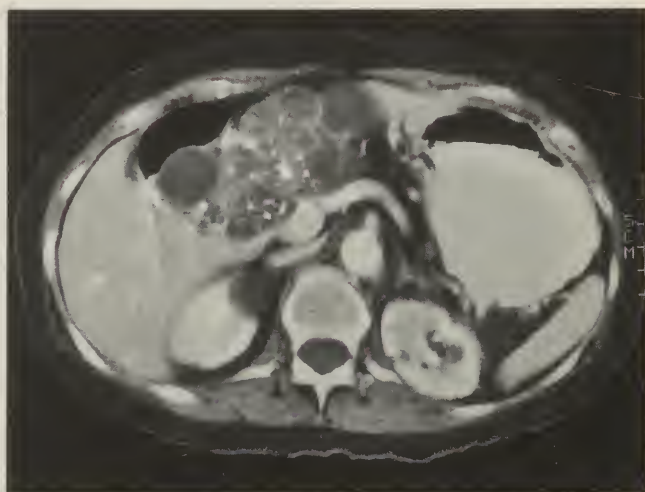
Representative CT scan of serous cystadenoma of the head of the pancreas. Note the central stellate calcification.
